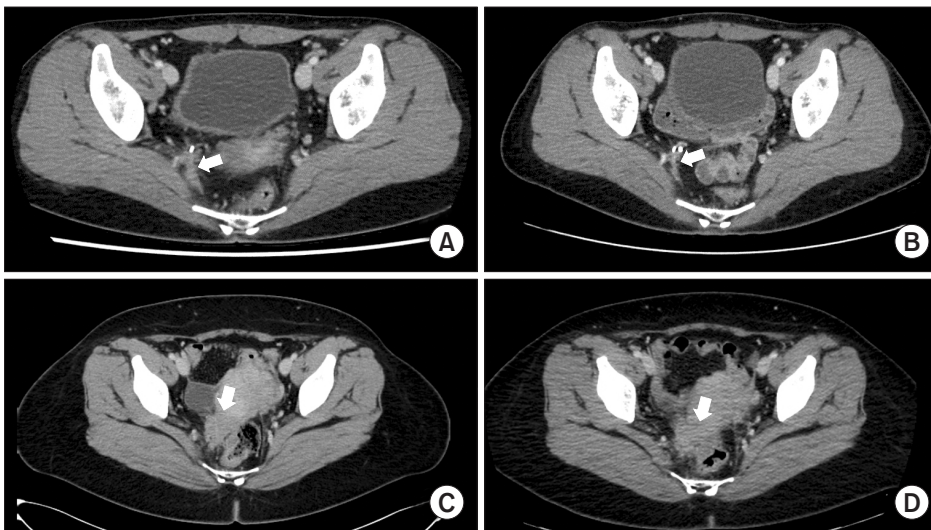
Evaluation of hormone response (arrow) in patients with hormone therapy. Computed tomography (CT) images of hormone responsive patient before hormone therapy (A) and after hormone therapy (B). CT images of hormone non-responsive patient before hormone therapy (C) and after hormone therapy (D).
